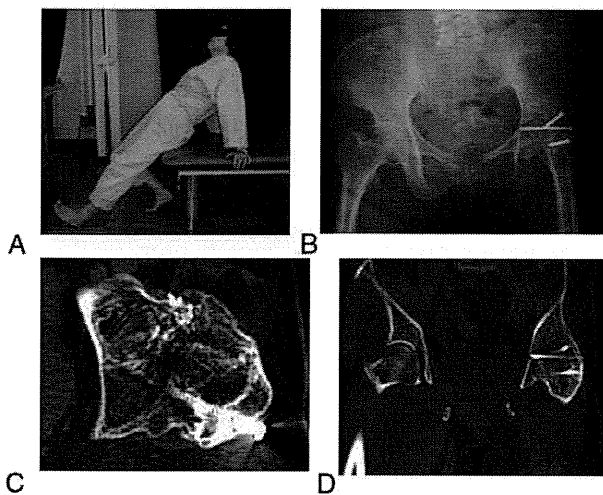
(A) A preoperative picture of the 59-year-old woman. She could not sit on a chair. (B) A preoperative radiograph and computed tomograms (C, axial section, and D, coronal section) are shown.
